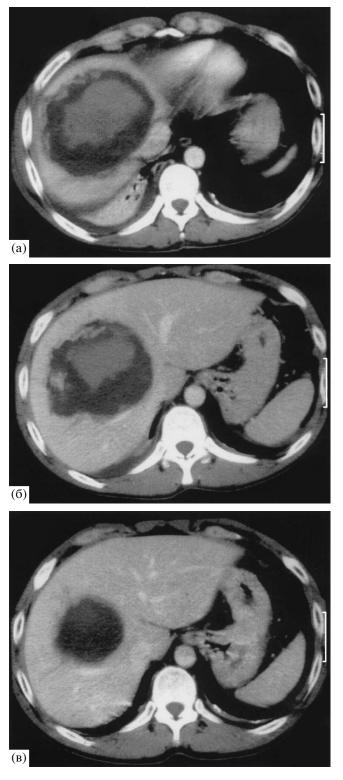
Case two. 5a. CT injury severity grade IV of the liver: extensive central hematoma. 56. CT two weeks later. 58. CT 14 months later. Рис. 5. Компьютерная томограмма печени пациента
